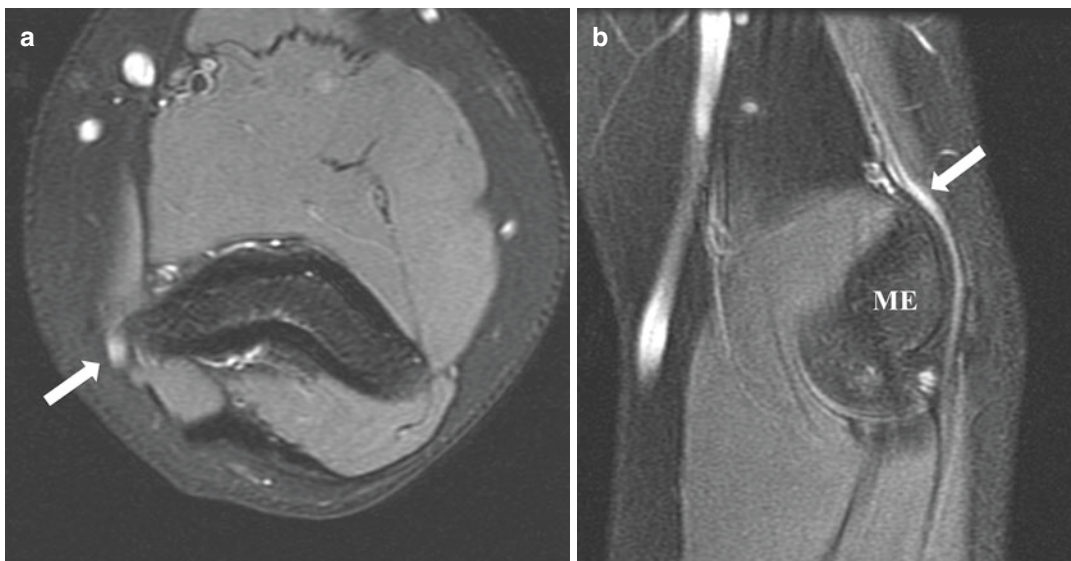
Overhead throwing athlete with recalcitrant ulnar neuropathy despite conservative management. Axial (a) and sagittal (b) T2 FSE MR images with fat saturation
